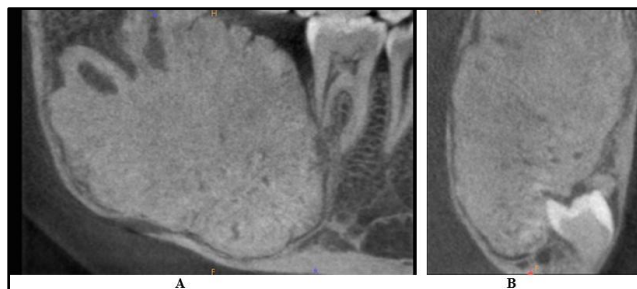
A and B: Panoramic and coronal sections of CBCT reveals large radiopaque mass with homogenous internal density and impacted 47. Significant expansion of the buccal and lingual cortices noted.
